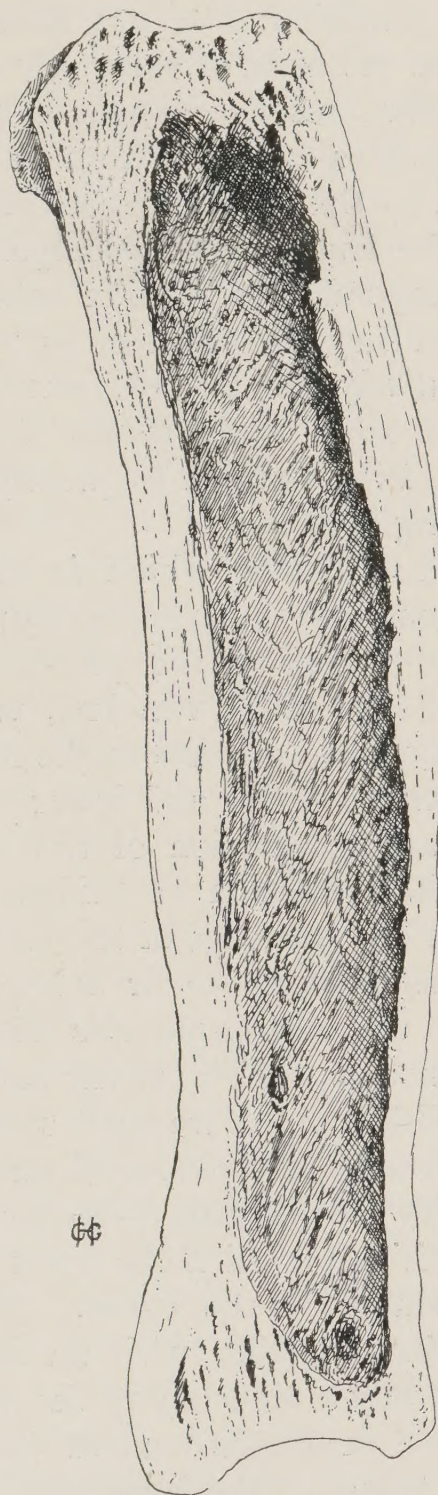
OSTEITIS DEFORMANS. INTERNAL ASPECT OF FIG. 85.
